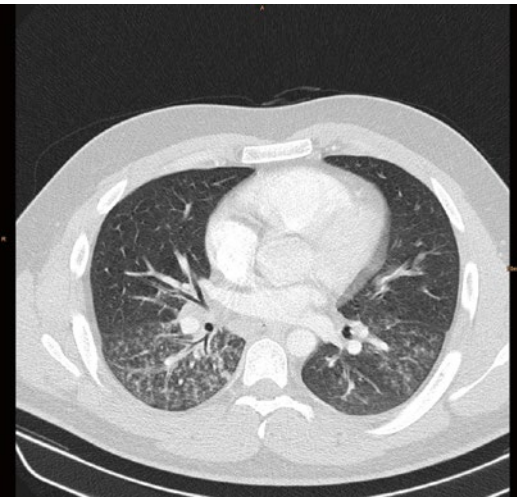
Same patient as in Fig. 20: CT scan showing centrilobular nodules, tree-in-bud, and bronchial wall thickening in both lower lobes
